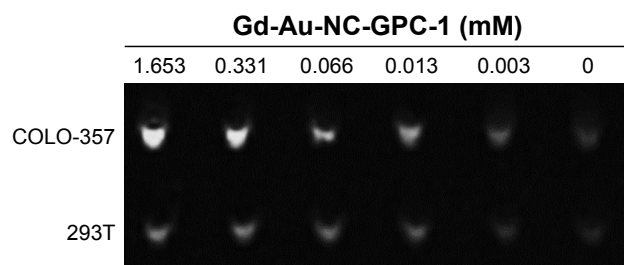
In vitro MRI study with COLO-357 and 293T cells.
